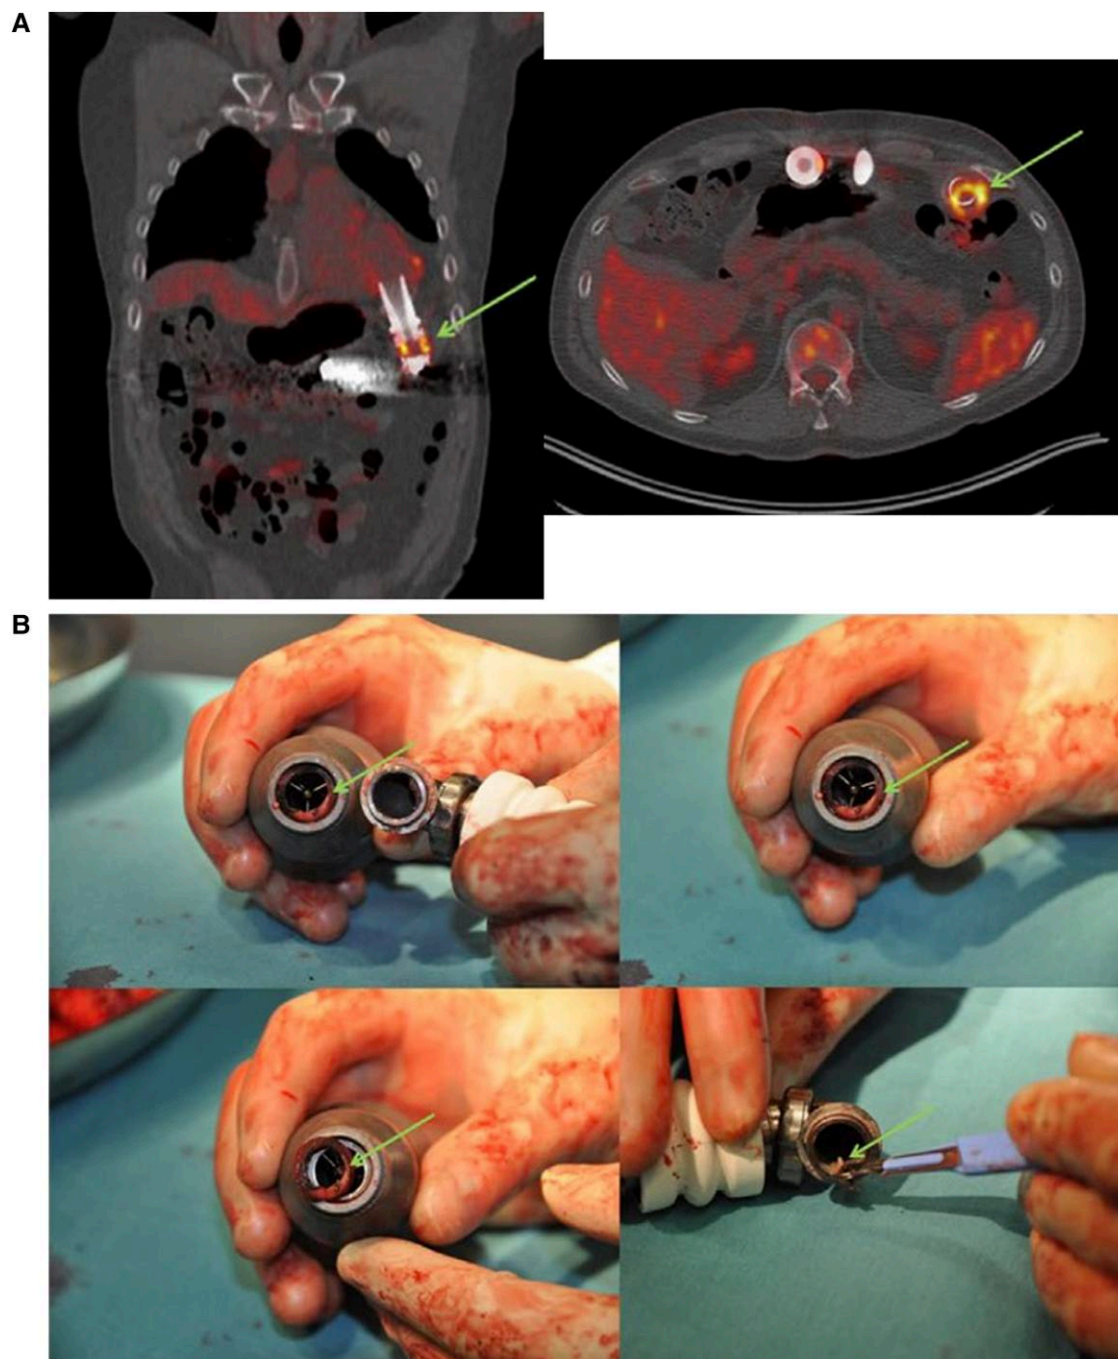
Example of FDG PET/CT scan from a patient with LVAD infection. Modified with permission from Akin *et al.*¹³⁴ (A) Case A1: 18F-FDG PET/CT images of a high FDG ring around the inflow cannula of the LVAD. Banded ring (indicated by arrows) with high degree of accumulation in the connection part of the inflow cannula with the housing. (B) Case A1: picture of the debris we found in the connection between inflow cannula and pump housing (hands of Dr A.P.W.M. Maat). 18F-FDG PET/CT, 18F-fluorodeoxyglucose positron emission tomography/computed tomography; LVAD, left ventricular assist device.
